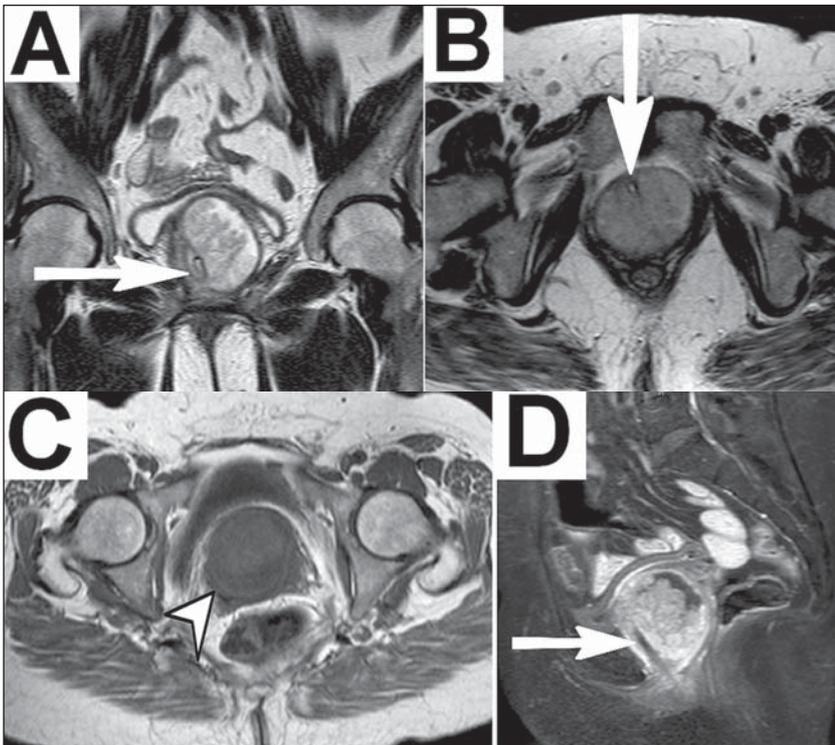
MRI of the pelvis. A,B: Coronal and axial T2-weighted sequences showing, respectively, cystic formation involving the urethra (showing hyperintense signal) and the UD, measuring approximately 5.5 × 5.3 × 5.4 cm. Within the diverticulum, an extensive solid expansive formation with intermediate signal can be seen. The urethral trajectory was identified after a urethral catheter had been inserted (arrows). C: A T1-weighted sequence showing the UD with hypointense signal (arrowhead). D: A T1-weighted sequence with fat saturation, after intravenous administration of paramagnetic contrast, highlighting the solid expansive component and the urethral catheter (arrow).
